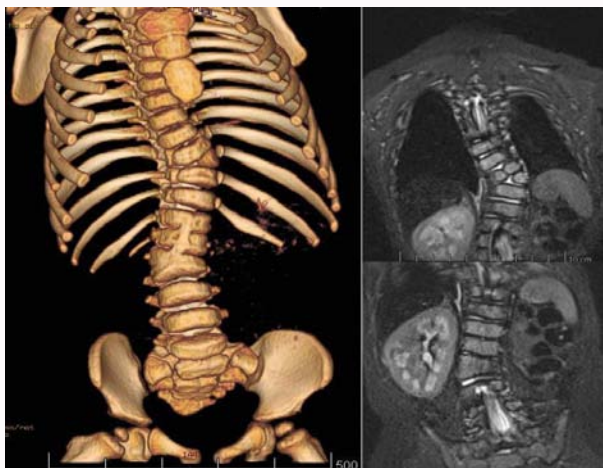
3D-CT and MRI revealing the supernumerary T11 segmented and the L2 hemisegmented hemivertebrae.
